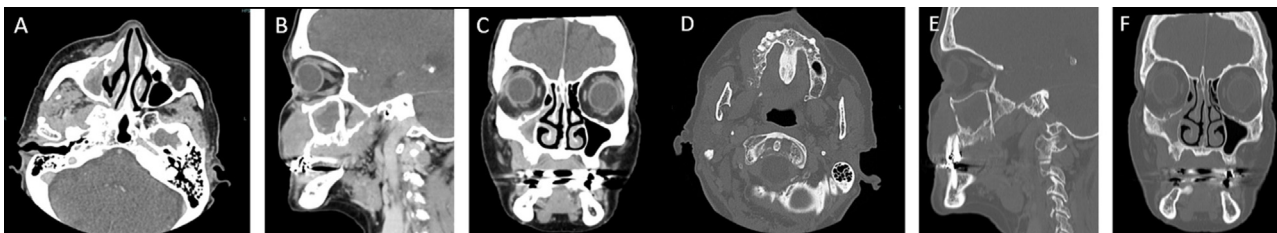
Contrast enhanced CT facial bones: (A) Axial, (B) Sagittal and (C) Coronal soft tissue windows demonstrate an enhancing soft tissue mass extending from the right gingivobuccal sulcus along the anterior maxillary wall, with invasion into the right orbit and maxillary sinus (D) Axial, (E) Sagittal and (F) Coronal bone windows demonstrate osseous involvement of the maxillary alveolus and anterior maxillary sinus wall. Enlargement of the infraorbital foramen indicating perineural spread is also well visualized on coronal bone window (F) with abnormal soft tissue in the pterygopalatine fossa (A).
